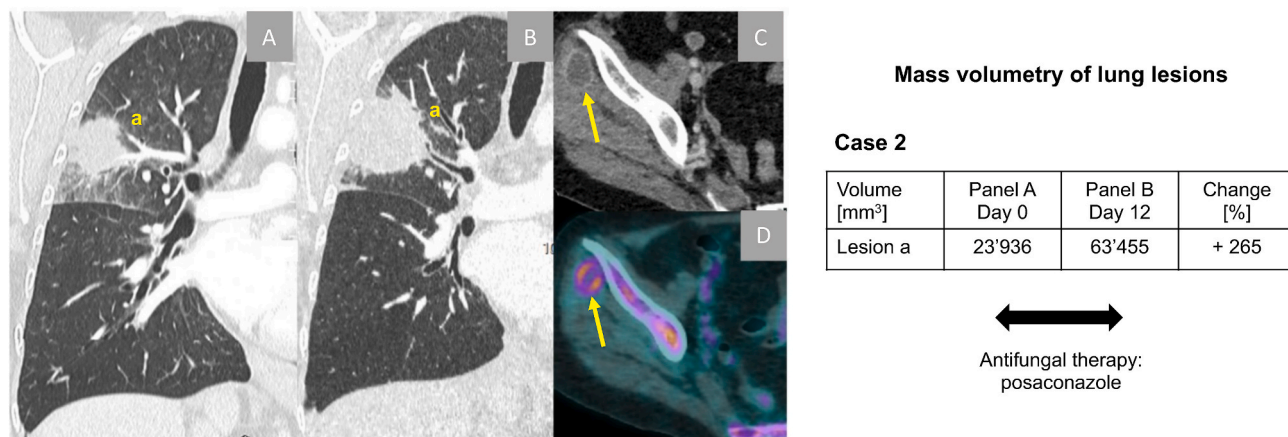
Radiological assessment of infection at baseline and in follow-up (Case 2) CT-scan images (sagittal view) of the lung lesions of Case 2 (A and B), as well as PET-CT imaging of the right *gluteus minimus* abscess (C and D). Chest CT pictures are taken at initial diagnosis (A) and at day +12 following introduction of posaconazole therapy and before the surgical intervention (B). Volume of the lung lesion is shown in the table with expression of the changes (in percent) in the follow-up image (B) compared to the baseline image (A).
